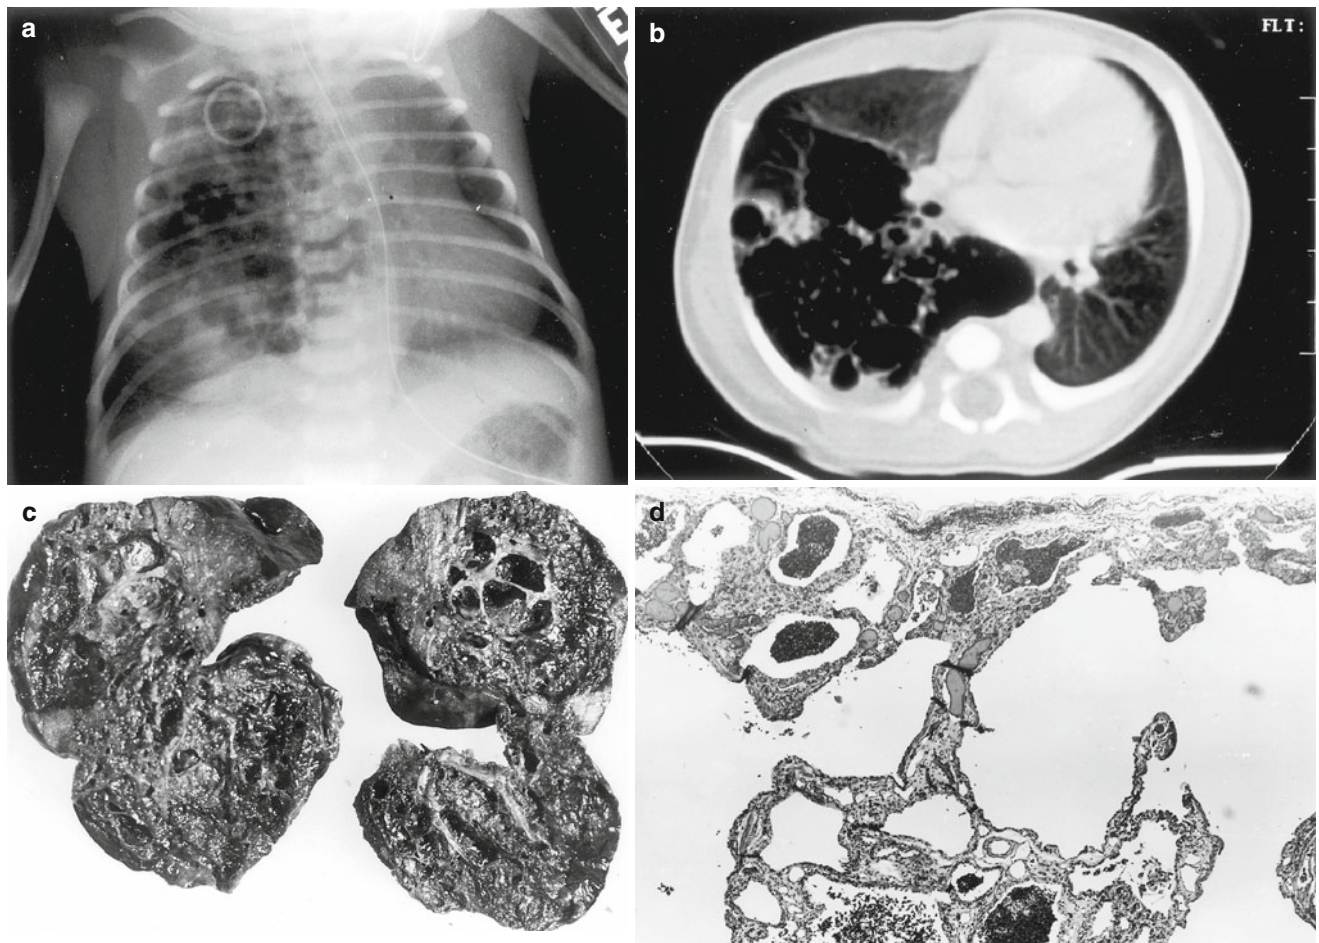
Cystic adenomatoid malformation, type I. Eight-day-old male with progressive respiratory distress since birth. (a) Chest X-ray reveals multiple large cysts within the right upper lobe with a shift of mediastinal structures to the left chest. (b) CT scan shows the cysts and compression of the right lower and middle lobes in more detail. (c) The
